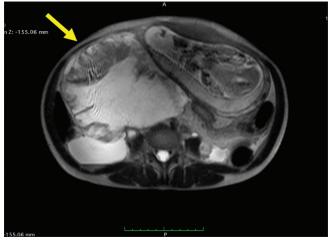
Magnetic resonance imaging done at 21 5/7 weeks of gestation showing the presence of multiloculated cystic masses (arrow) predominantly occupying the right hemiabdomen and pelvis
